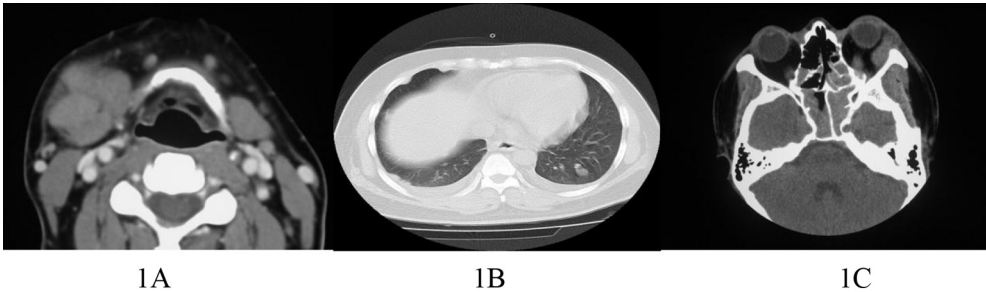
A: Cervical CT scanning with no contrast showed right submandibular multi-lymphadenopathy, with a maximal size of 32 mm × 19 mm, that tended to fuse; B: Thoracic CT scanning with no contrast showed multiple pleural nodules and a nodule at the left lower lung; C: Orbital CT scanning with no contrast presented localized swelling of the left lateral rectus and that the right optic nerve was enveloped by mass at the posterior oculus region.
